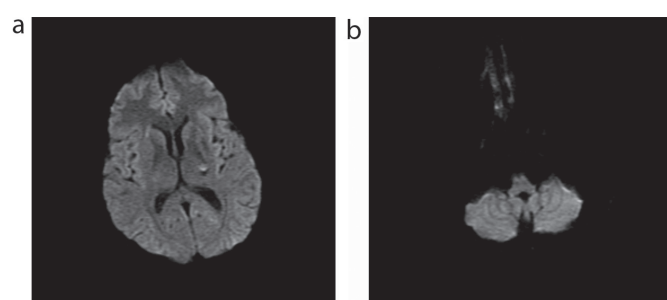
a,b. (a) Axial diffusion-weighted MRI scan 2 months after second discharge, showing resolution of the lesions periventricularly, while a small lesion with high signal intensity remains in the posterior limb of the left internal capsule, (b) The lesion in the medulla oblongata in the brainstem has resolved completely.
